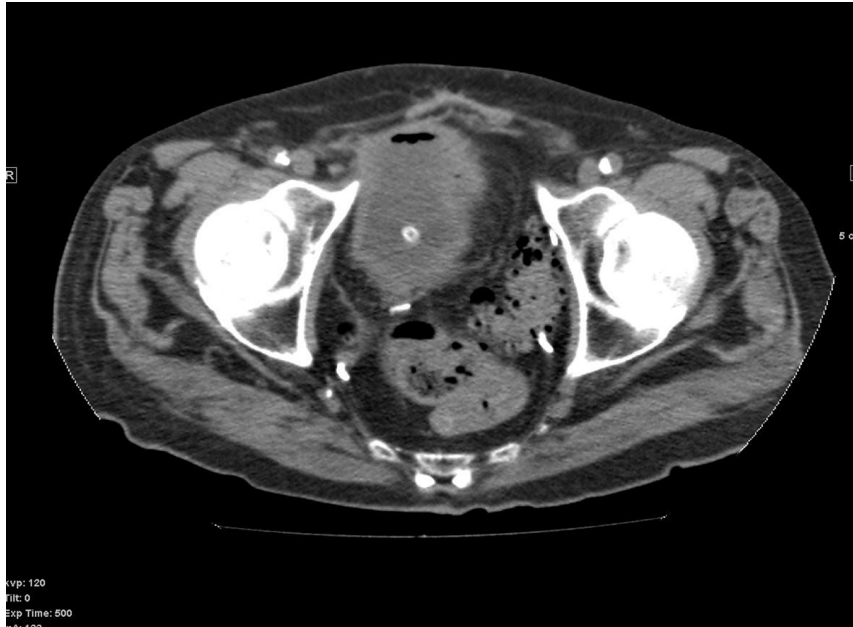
Pneumatosis of the neobladder detected on direct CT scan at the onset of symptomatology.
